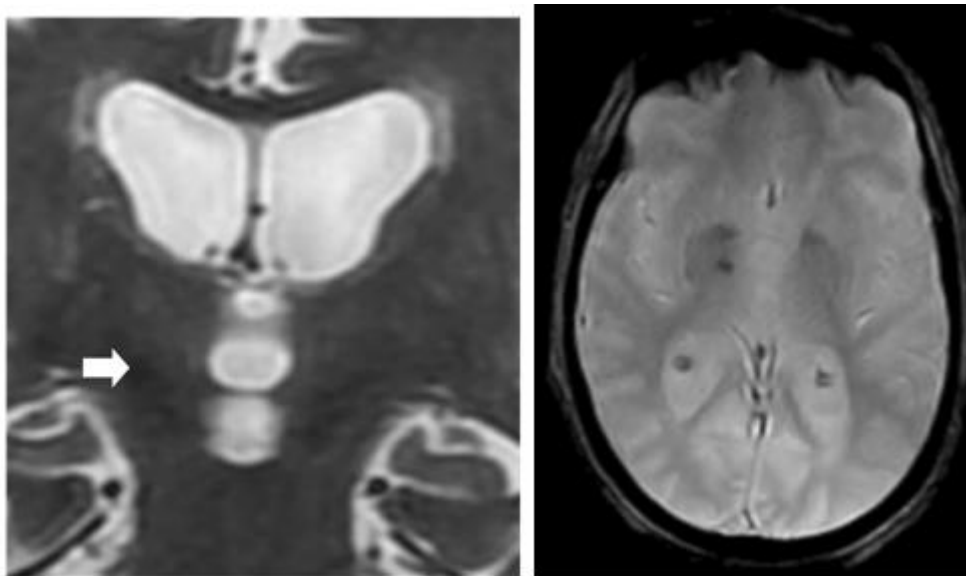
MRI of the patient 2 months postevent. Coronal T2-weighted and gradient-echo (T2*) MRIs show a focal haemorrhage in the right subthalamic nucleus.
